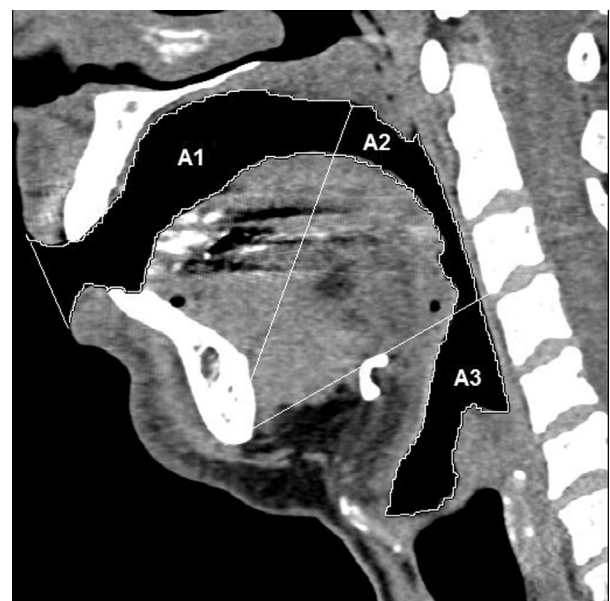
Areas (mm^2) measured in CT midsagittal images: oral cavity (A1), pharyngeal region (A2), and epilaryngeal region (A3).
